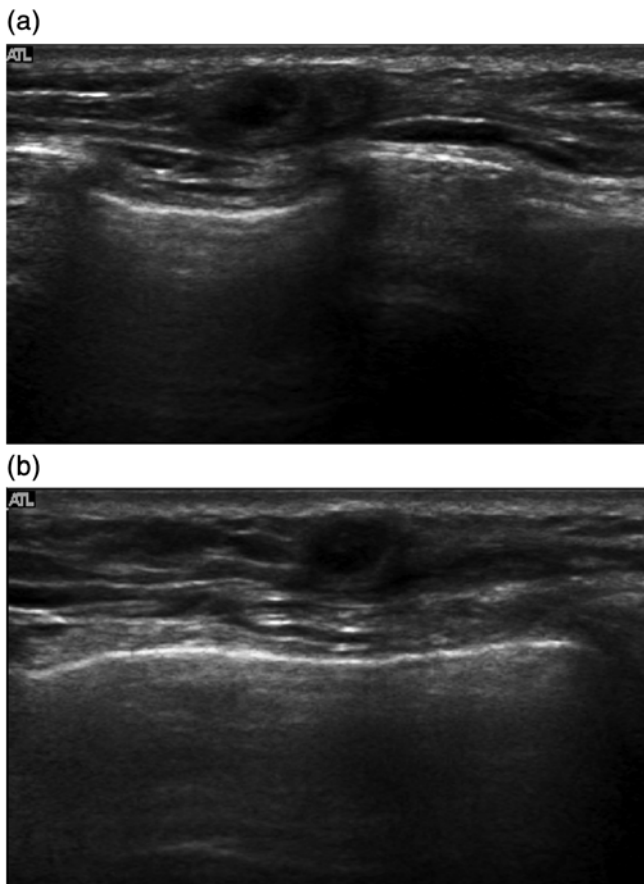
A 66-year-old woman with a palpable lesion after left mastectomy. (a) Transverse and (b) longitudinal sonography revealed a 15-mm-size complex echogenic nodule at the left chest wall. This lesion was assessed as category 4a, and US-guided core-needle biopsy was performed. Pathology results showed fat necrosis
